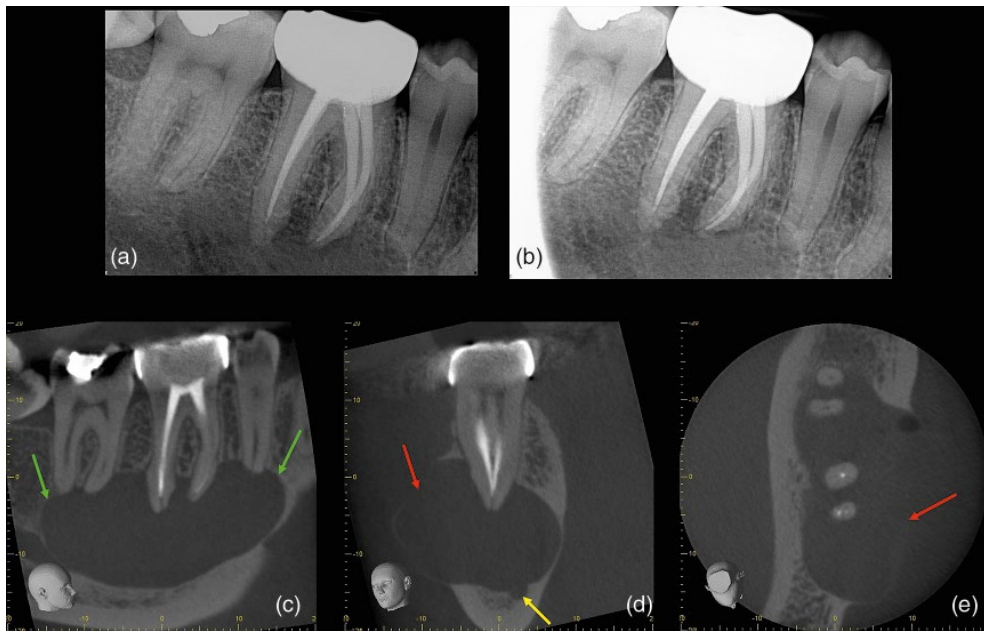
Radicular cyst. (a, b) Parallax periapical radiographs reveal a well-defined periapical radiolucency associated with the root treated lower right first molar tooth (green arrow). (c) Sagittal reconstructed CBCT scan reveals a well-defined periapical radiolucency extending from the lower right second premolar to the lower right second molar teeth which has resulted in apical resorption of the root apices. (d) coronal and (e) axial reconstructed CBCT slices reveal marked buccal expansion and perforation of the buccal cortical plate (red arrow). The inferior dental canal (yellow arrow) has been deflected inferiorly.
